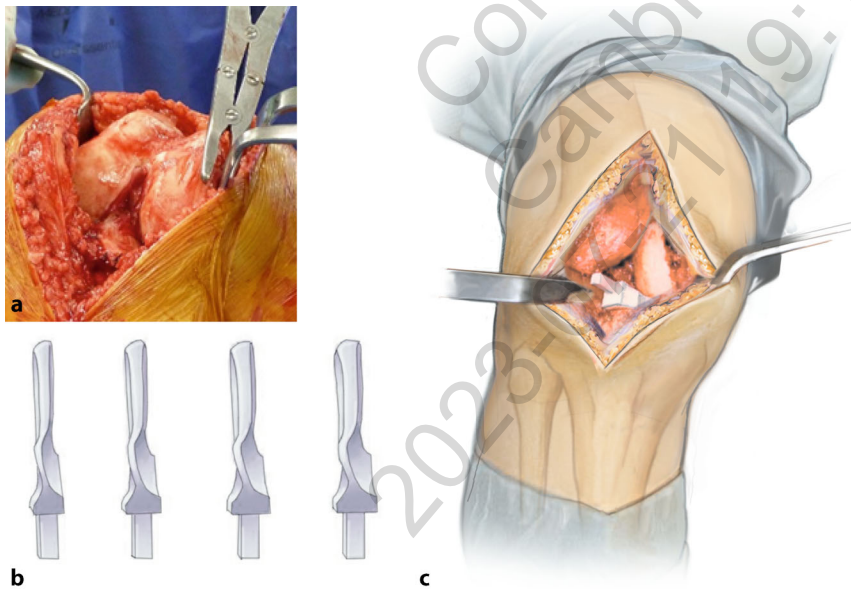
▲ Removal of osteophytes (Fig. 5) according to the iView™ planning protocol (Fig. 1; interfering osteophytes are labelled in red in the iView® plan). These two steps are crucial to correctly place the iJigs because the templates are referenced to the surface of the bone. Afterwards, the knee joint is balanced in extension using the patient-specific spacer blocks with incremental heights (A–D) (b). These spacers increase in height in 1 mm steps, with a patient-individual starting height as determined by the measurement of the extension gap in the preoperative CT scan. The optimal spacer block is confirmed by checking the stability of the ligaments in extension (c)
